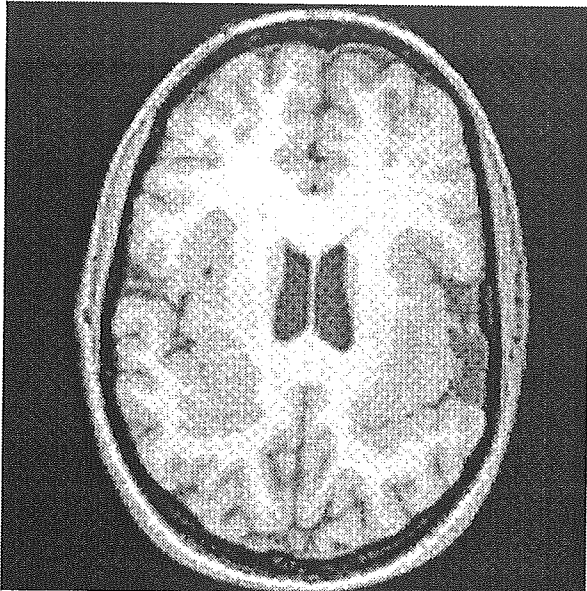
Axial T₁-weighted magnetic resonance imaging section of patient 6 shows grossly malformed perisylvian regions bilaterally. Close analysis of the malformation suggests a polymicrogyric pattern.
